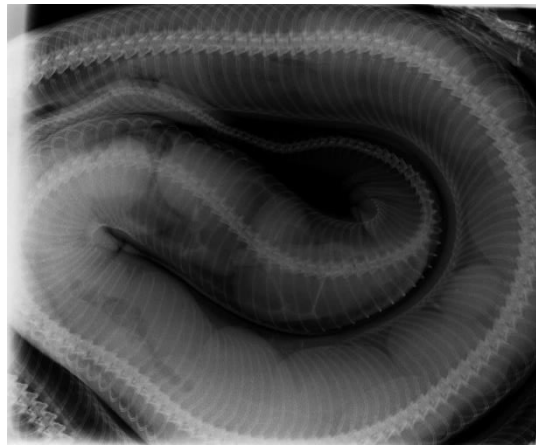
Radiography image of eggs found in the cealomic cavity.
